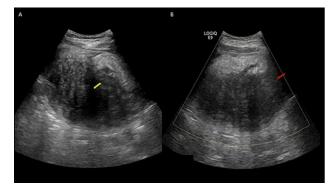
Follow up abdominal ultrasound (A & B) showing change in texture of the mass, which became more hypoechoic (Yellow arrow) with a vascularity by Doppler study (Red arrow), indicating necrotic changes.
